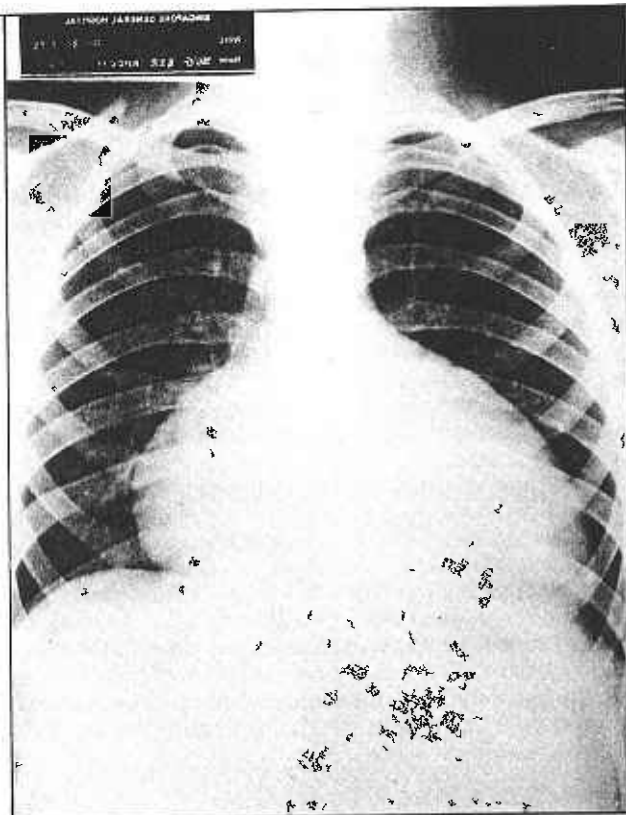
Chest roentgenogram showing gross cardiomegaly with giant right atrium and oligemic lung fields (Ebstein's anomaly).
